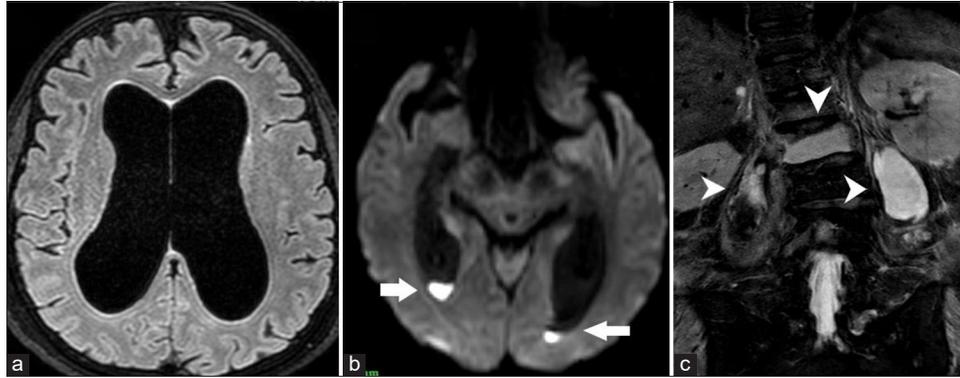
(a) Magnetic resonance imaging axial T2 image showing communicating hydrocephalus. (b) Diffusion-weighted images showing collection in ventricles-ventriculitis (arrows). (c) Coronal short-tau inversion recovery sequence showing bilateral psoas and intraosseous collections (arrowheads).
